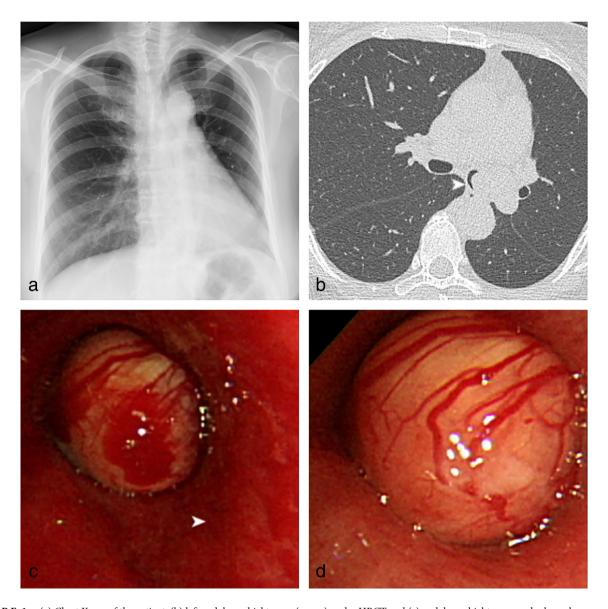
(a) Chest X-ray of the patient, (b) left endobronchial tumor (arrow) under HRCT and (c) endobronchial tumor under bronchoscopy. A left main bronchial tumor was located 0.5–1 cm below the main carina (arrow); (d) Close-up view of the endobronchial tumor
